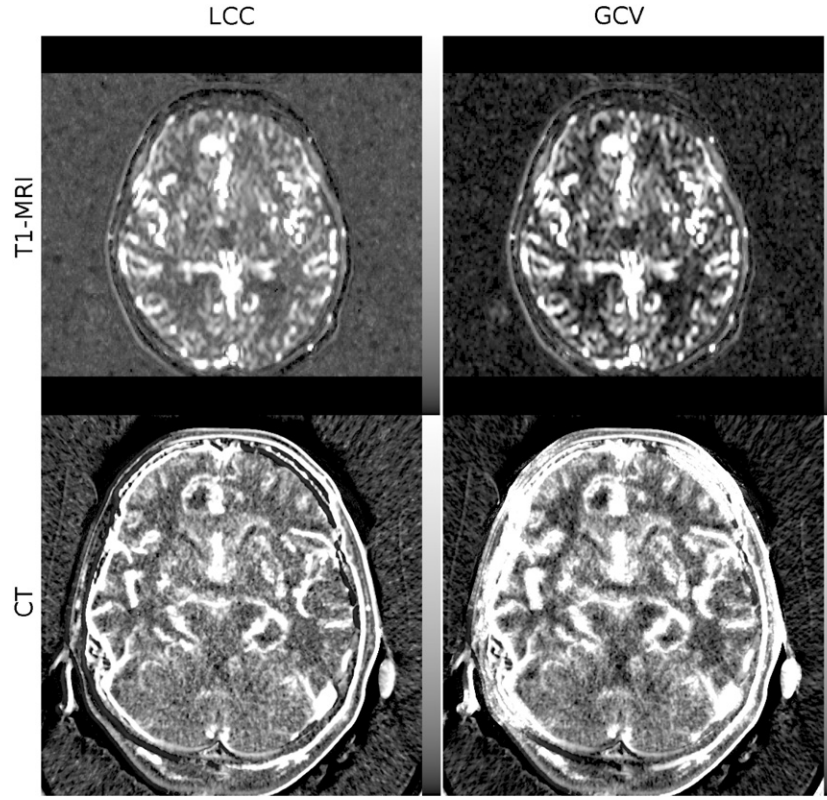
Same maps, grey scales and methods as in figure 5 (top row, MRI data) and figure 6 (bottom row, CT data), but with additional smoothing on the cost functions. The smoothing windows (w_s , w_μ) for these data are set to (5, 13) (top left), (3, 1) (top right), (7, 1) (bottom left) and (13, 1) (bottom right). Note that, with these settings, both over- and underregularized values disappear (compared to figures 5 and 6).
